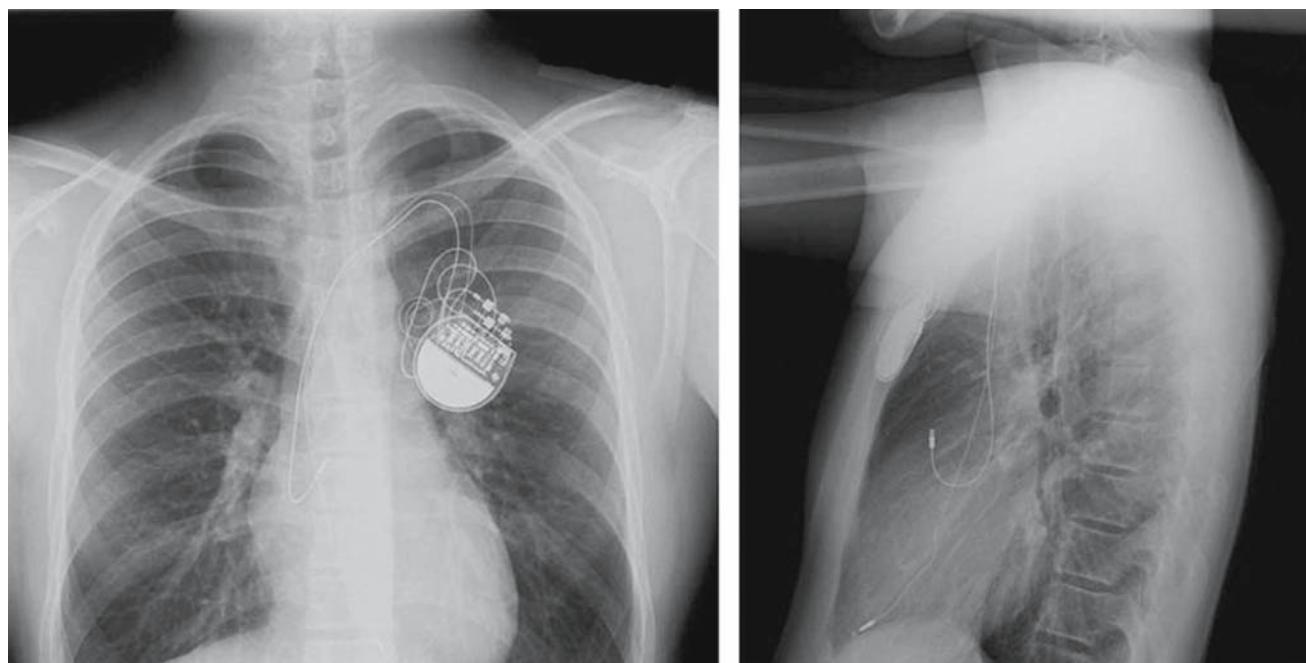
Chest x-rays of an endocardial, dual-chamber pacing system in a young patient (left, anterior view; right, lateral view; Sainte-Justine Hospital, Montreal, Quebec, Canada; used with permission). The implantable pulse generator (IPG, pacemaker) is implanted in the left pectoral region. The superior lead is implanted in the right atrial appendage, and the inferior lead is in the right ventricular apex.
